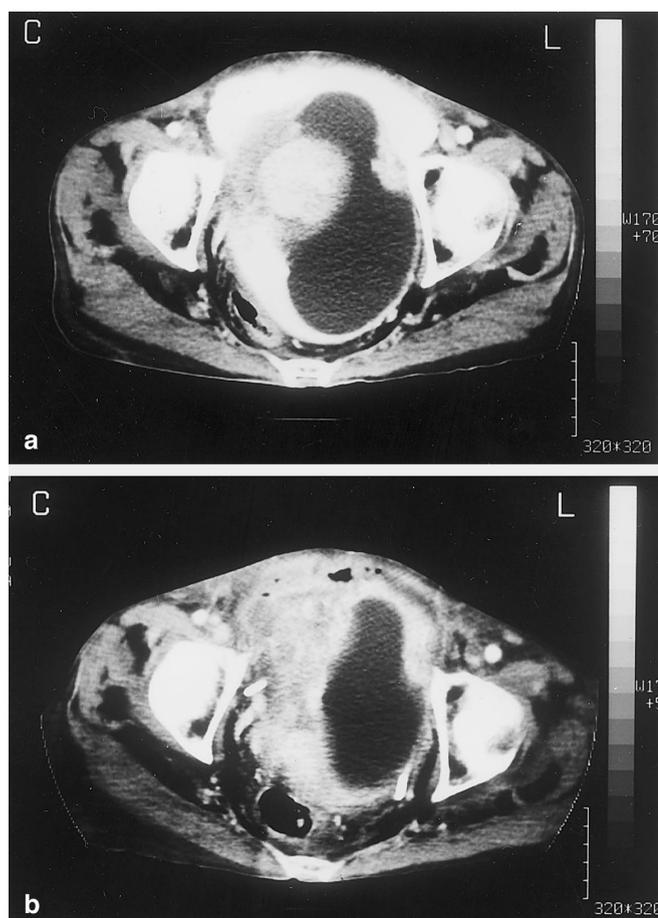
Computed tomography (CT) scan film of the pelvis of patient 4 before (a) and after (b) treatment. The patient had a giant tumor of ovarian cancer in the pelvis. After treatment the tumor decreased 30% in size (b)
